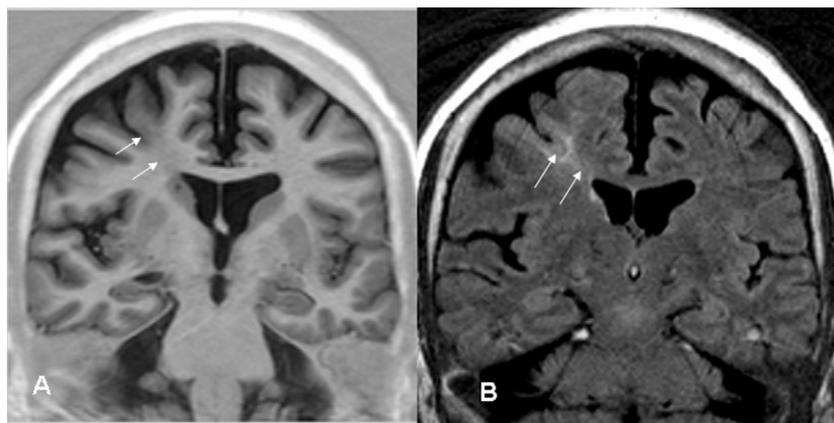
(A) Inversion recovery (IR) and (B) fluid attenuation inversion recovery (FLAIR) MRI sequence showing a transmantle focal cortical dysplasia in the superior and middle frontal gyrus at the right side.
